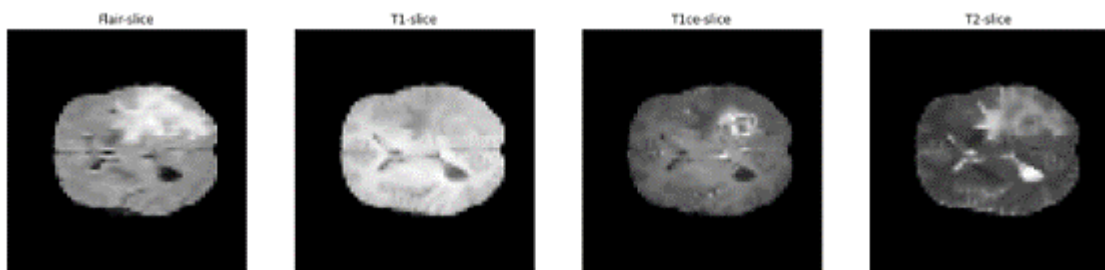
The 4 different type of MRI scans. The images are generated by using BRATS 2019 data
